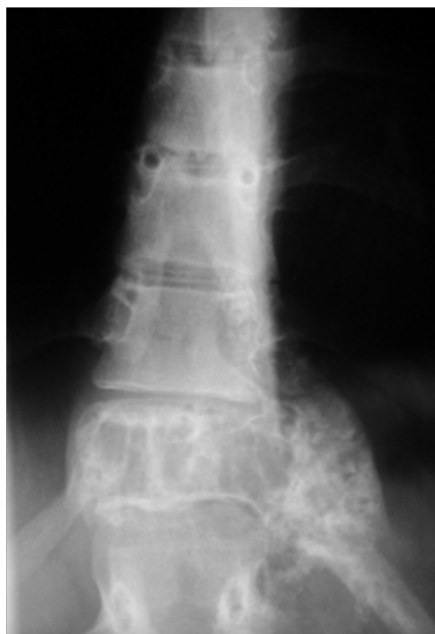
AP X-ray of thoracic spine demonstrated an ill-defined osteolytic lesion on the left in the twelfth thoracic vertebra with erosion of the pedicle and transverse process and involvement of the left costovertebral joint with soft tissue shadow and calcification
